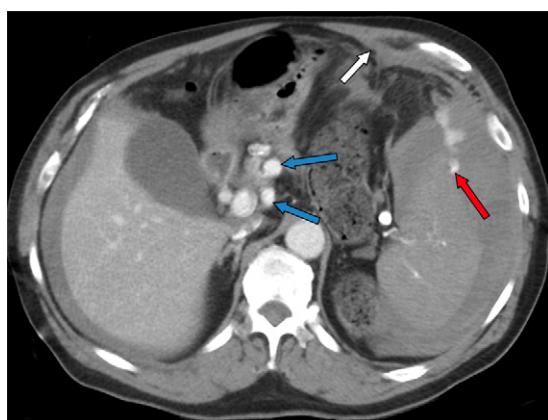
Grade V splenic injuries according to the revised 2018 AAST-OIS. Axial contrast-enhanced CT image in a 67-year-old man after a motor vehicle collision shows extensive parenchymal disruption, hemoperitoneum (white arrow), and active extravasation beyond the spleen and into the peritoneum (red arrow). Extensive periportal collaterals (blue arrows) are noted related to portal hypertension from chronic liver disease. The patient was treated with exploratory laparotomy and splenectomy. An axial cine clip of this patient is shown in Movie 5.
